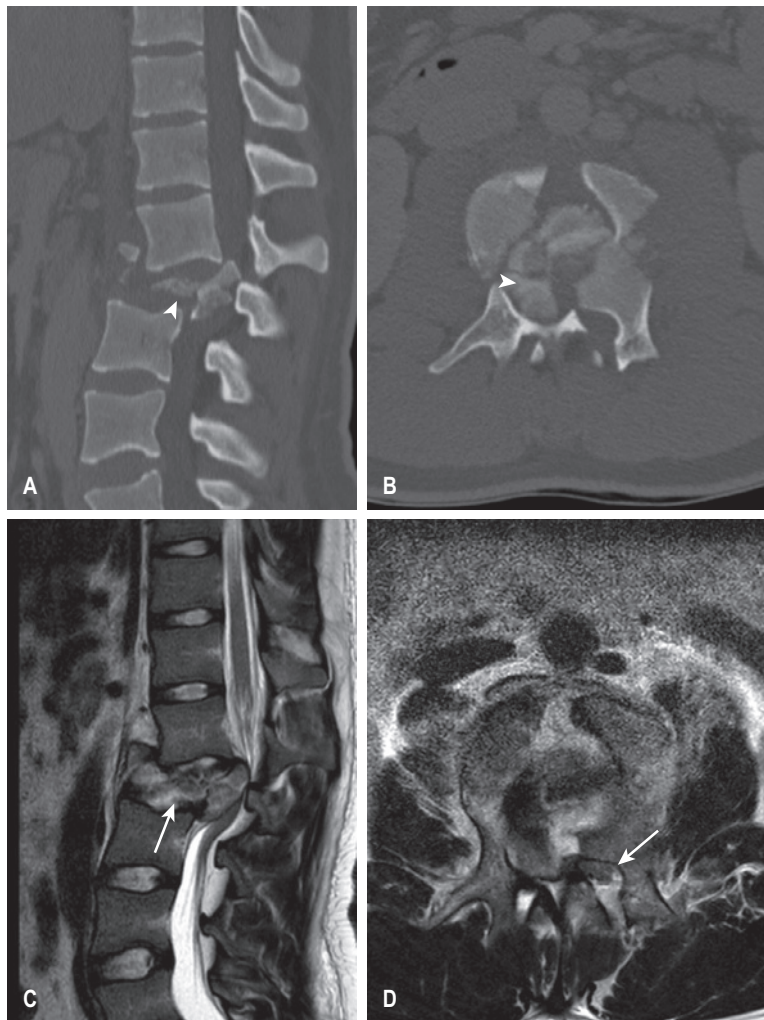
Sagittal and axial Computed Tomography (A, B) and T2-weighted Magnetic Resonance Imaging (C, D) sequences of the thoracolumbar spine demonstrating a burst fracture (white arrow heads) with retropulsed fragments completely effacing the spinal canal. The cauda equina is compressed and displaced towards the left (long white arrow).
